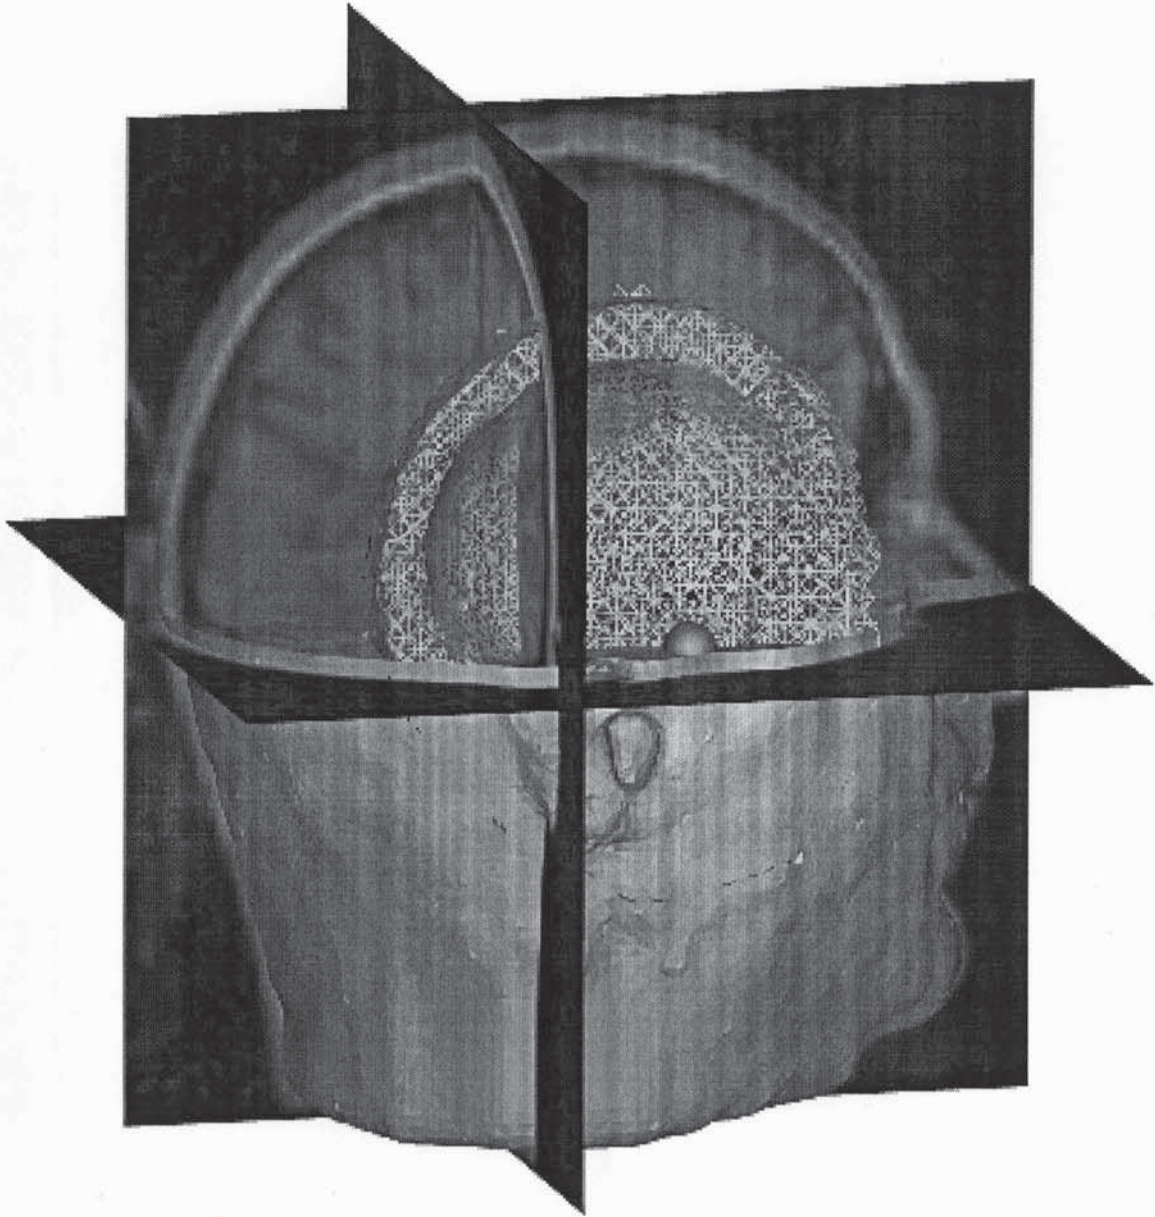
SOLUTION TO A SINGLE DIPOLE SOURCE FORWARD PROBLEM. THE UNDERLYING MODEL IS SHOWN IN THE MRI PLANES, THE DIPOLE SOURCE IS INDICATED WITH THE RED AND BLUE SPHERES, AND THE ELECTRIC FIELD IS VISUALIZED BY A CROPPED SCALP POTENTIAL MAPPING AND A WIRE-FRAME EQUIPOTENTIAL ISOSURFACE.
